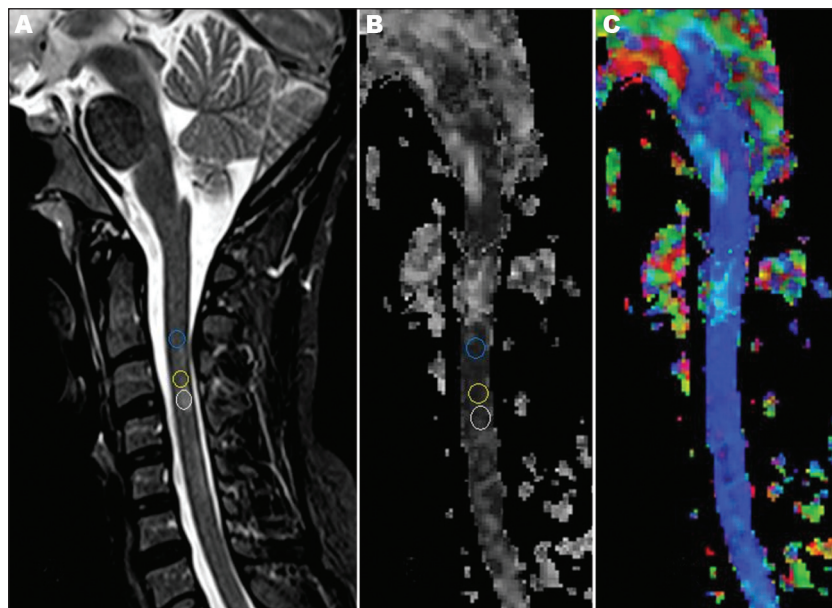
32-year-old female patient with MS. Cervical spine MRI showing sagittal STIR [A], FA map [B] and FA color map [C]. In A and B, the placement of the ROIs is demonstrated in the plaque (white), NASC around the plaque (yellow) and NASC more than 1cm from the plaque (blue). Note the artifacts in the FA and FA color maps above the blue ROI, which are common in the DTI of the spinal cord.
